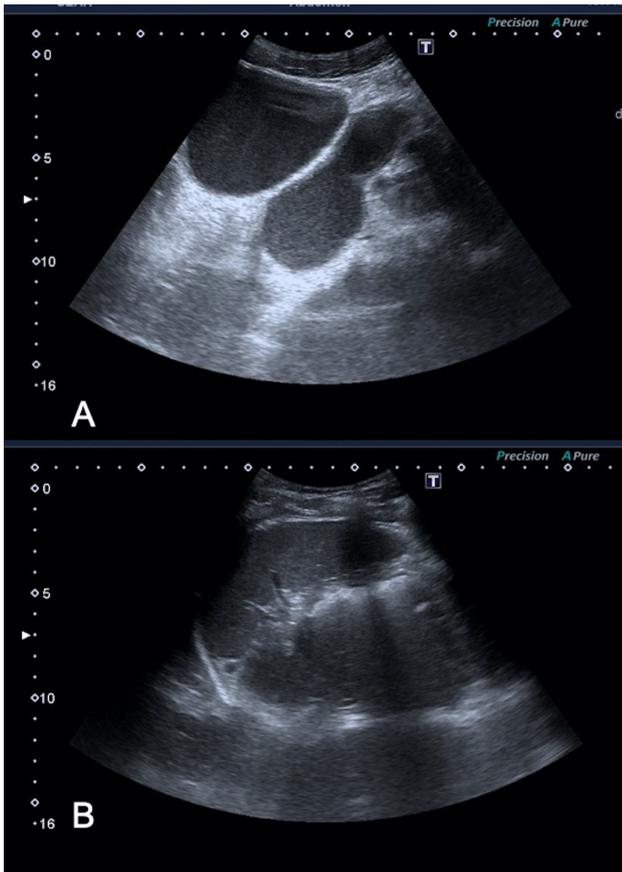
Ultrasound of the patient
